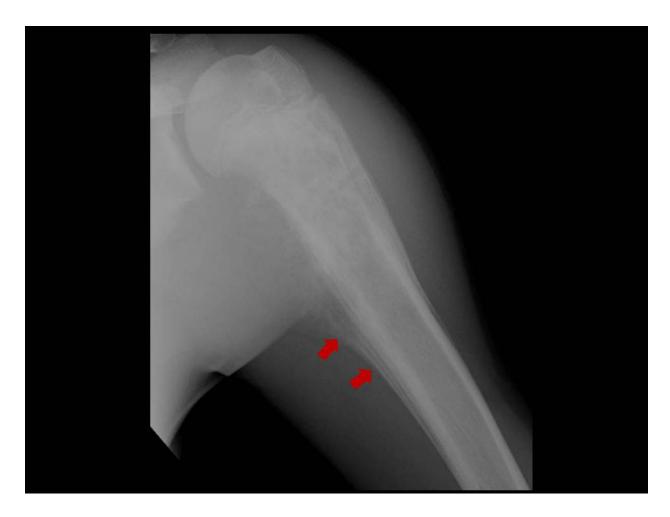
Ewing sarcoma. Anterior-posterior radiography reveals a poorly defined osteolytic lesion in the proximal metaphysis of the left humerus, with permeative bone destruction and periosteal "sunburst" and "onion skin" like reaction.
